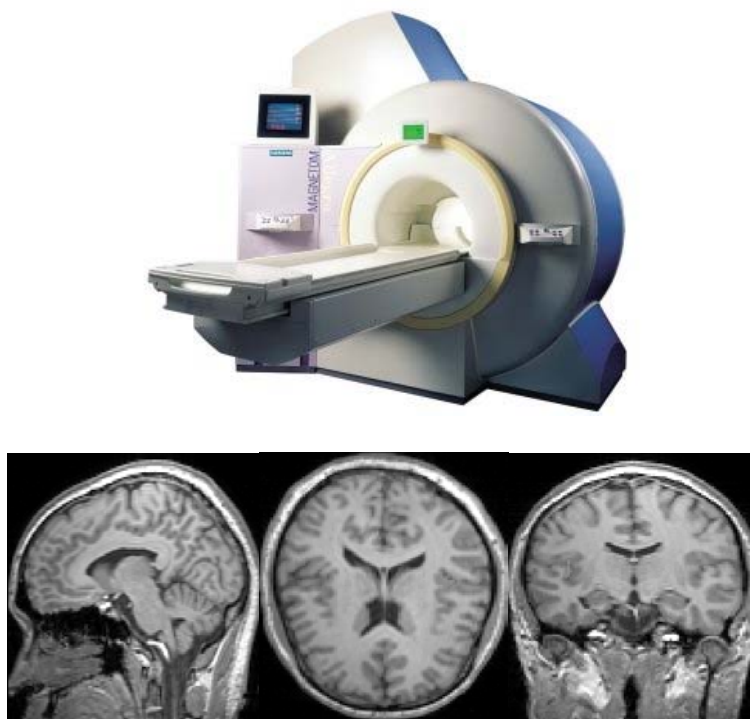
Typical clinical MRI Scanner and MR imaging of head (sagittal, transverse and coronal views)
